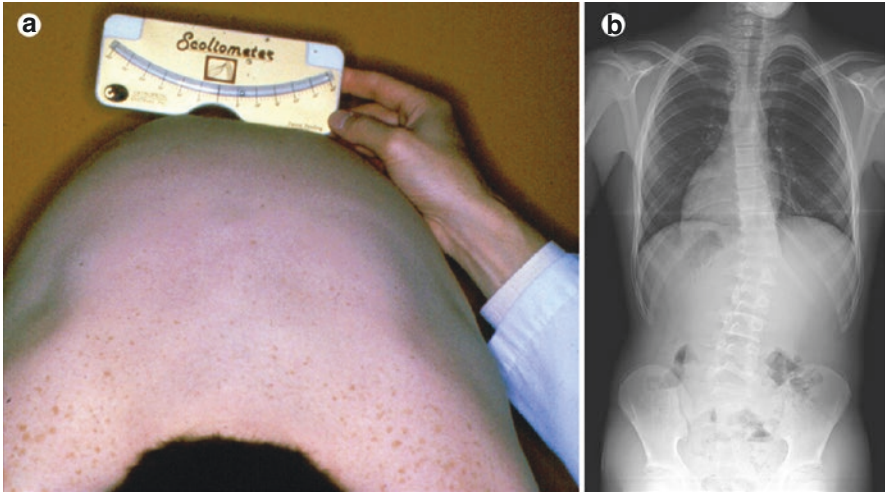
Screening for scoliosis by clinical exam and radiography. (a) Scoliometer measurement during Adams forward bend test. (b) Long-standing posterior-anterior radiograph of a 13-year-old boy showing a 30° curve and Risser 2. From Weinstein *et al.* 2008, Fig. 1, page 1528 [110]
